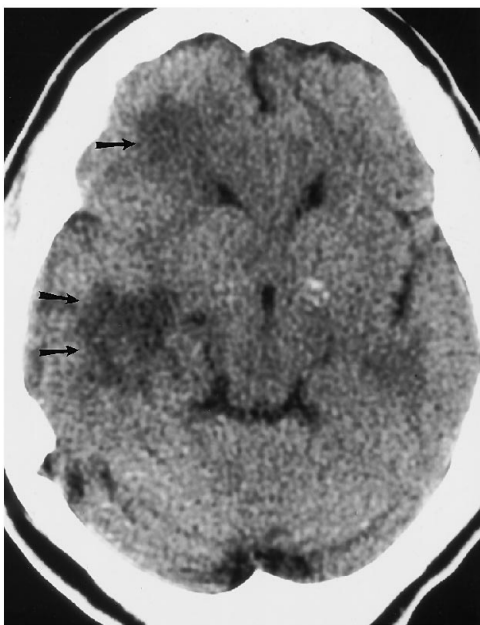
CT scan obtained during the most recent admission for left-sided weakness shows low-attenuation regions within the right temporoparietal and right frontal white matter (arrows). Postcontrast CT showed no enhancement of these regions (not shown).
